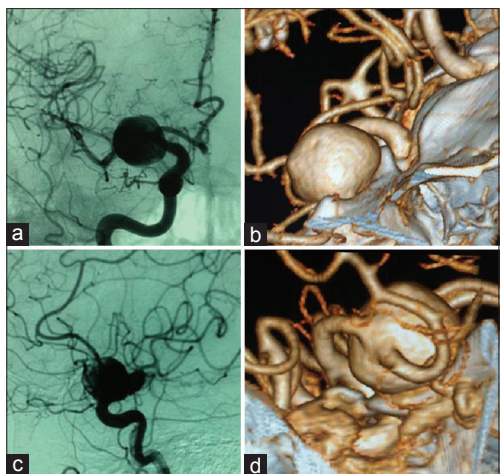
DSA at the anteroposterior (a) and lateral (b) positions showing a saccular aneurysm that is difficult to differentiate from the parent vessel. Three-dimensional CT angiography at the anterior-oblique (c) and posterior-oblique (d) positions confirming the diagnosis of an aneurysm with an undefined neck on the right MCA
